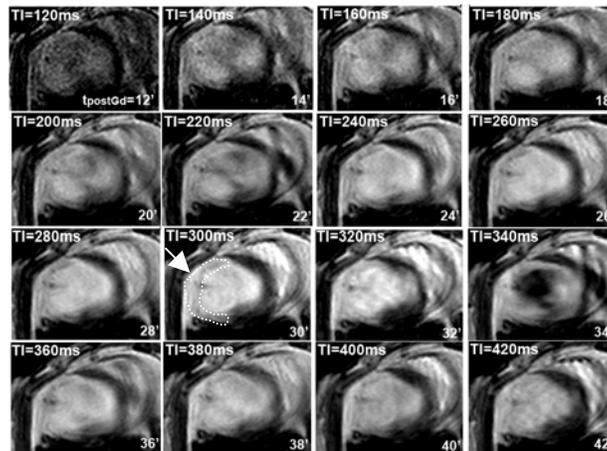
Short-axis MR images corresponding to each inversion time (TI) following Gd-DOTA injection (the dotted line shows the hyper-enhanced area corresponding to the infarcted myocardium at 30 minutes post-Gd-DOTA injection).
